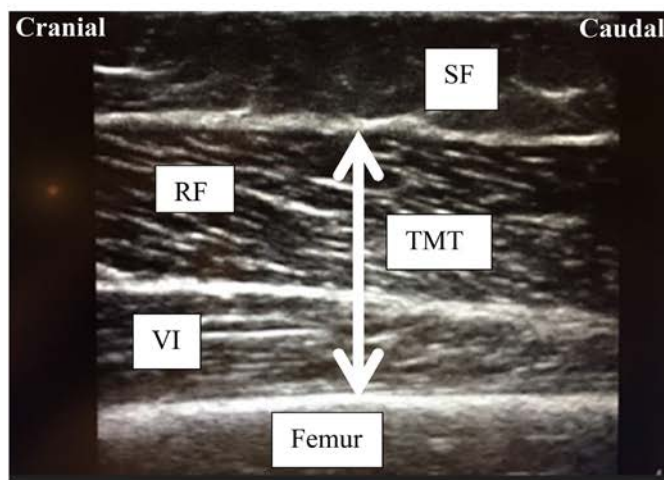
Ultrasound imaging of the right quadriceps muscle. A. The ultrasound probe was positioned on the anterior thigh and oriented in the transverse plane at a point that was two thirds of the distance from the medial aspect of the anterior superior iliac spine to the superior patella border. RF-CSA, rectus femoris cross-sectional area; VI, vastus intermedius; SF, superficial fascia. The dotted line traces the inner echogenic line of the RF fascia and outlines the RF-CSA. B. The ultrasound probe was positioned on the anterior thigh and orientated in the sagittal plane at a point that was two thirds of the distance from the medial aspect of the anterior superior iliac spine to the superior patella border. RF, rectus femoris; VI, vastus intermedius; TMT, total muscle thickness (RF + VI); SF, superficial fascia. The solid white arrow represents total muscle thickness, measured from the inner most aspect of the superficial fascia to the femur.
